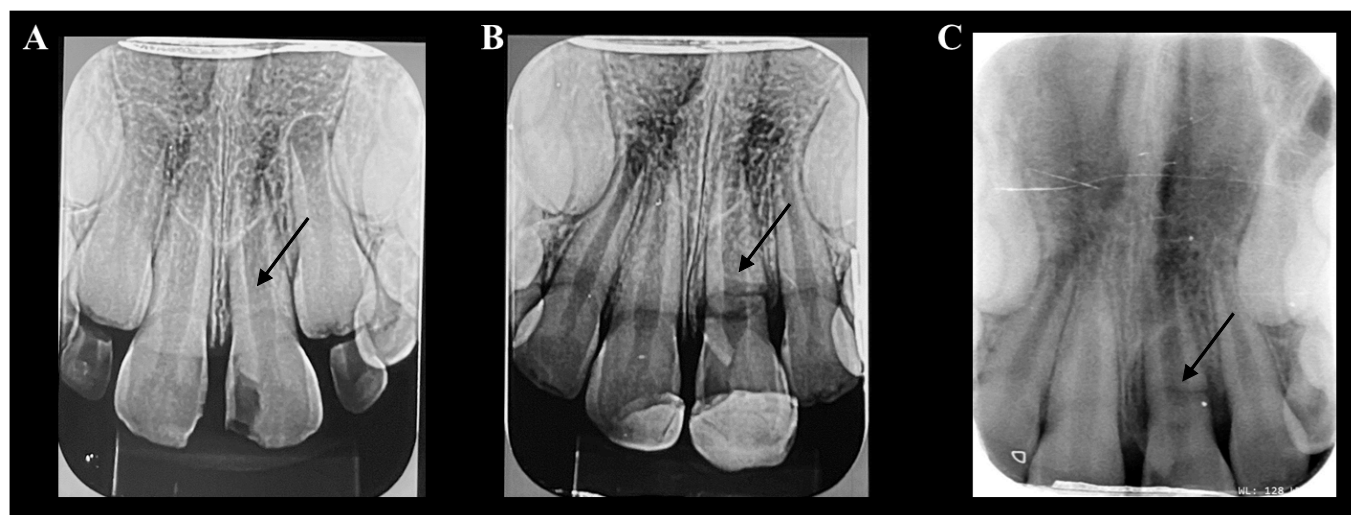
Radiographs taken at separate times.
